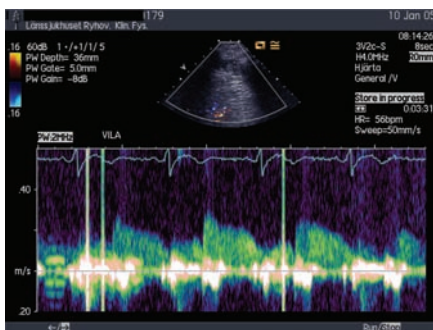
Spectral Doppler recording of the LAD flow at rest
